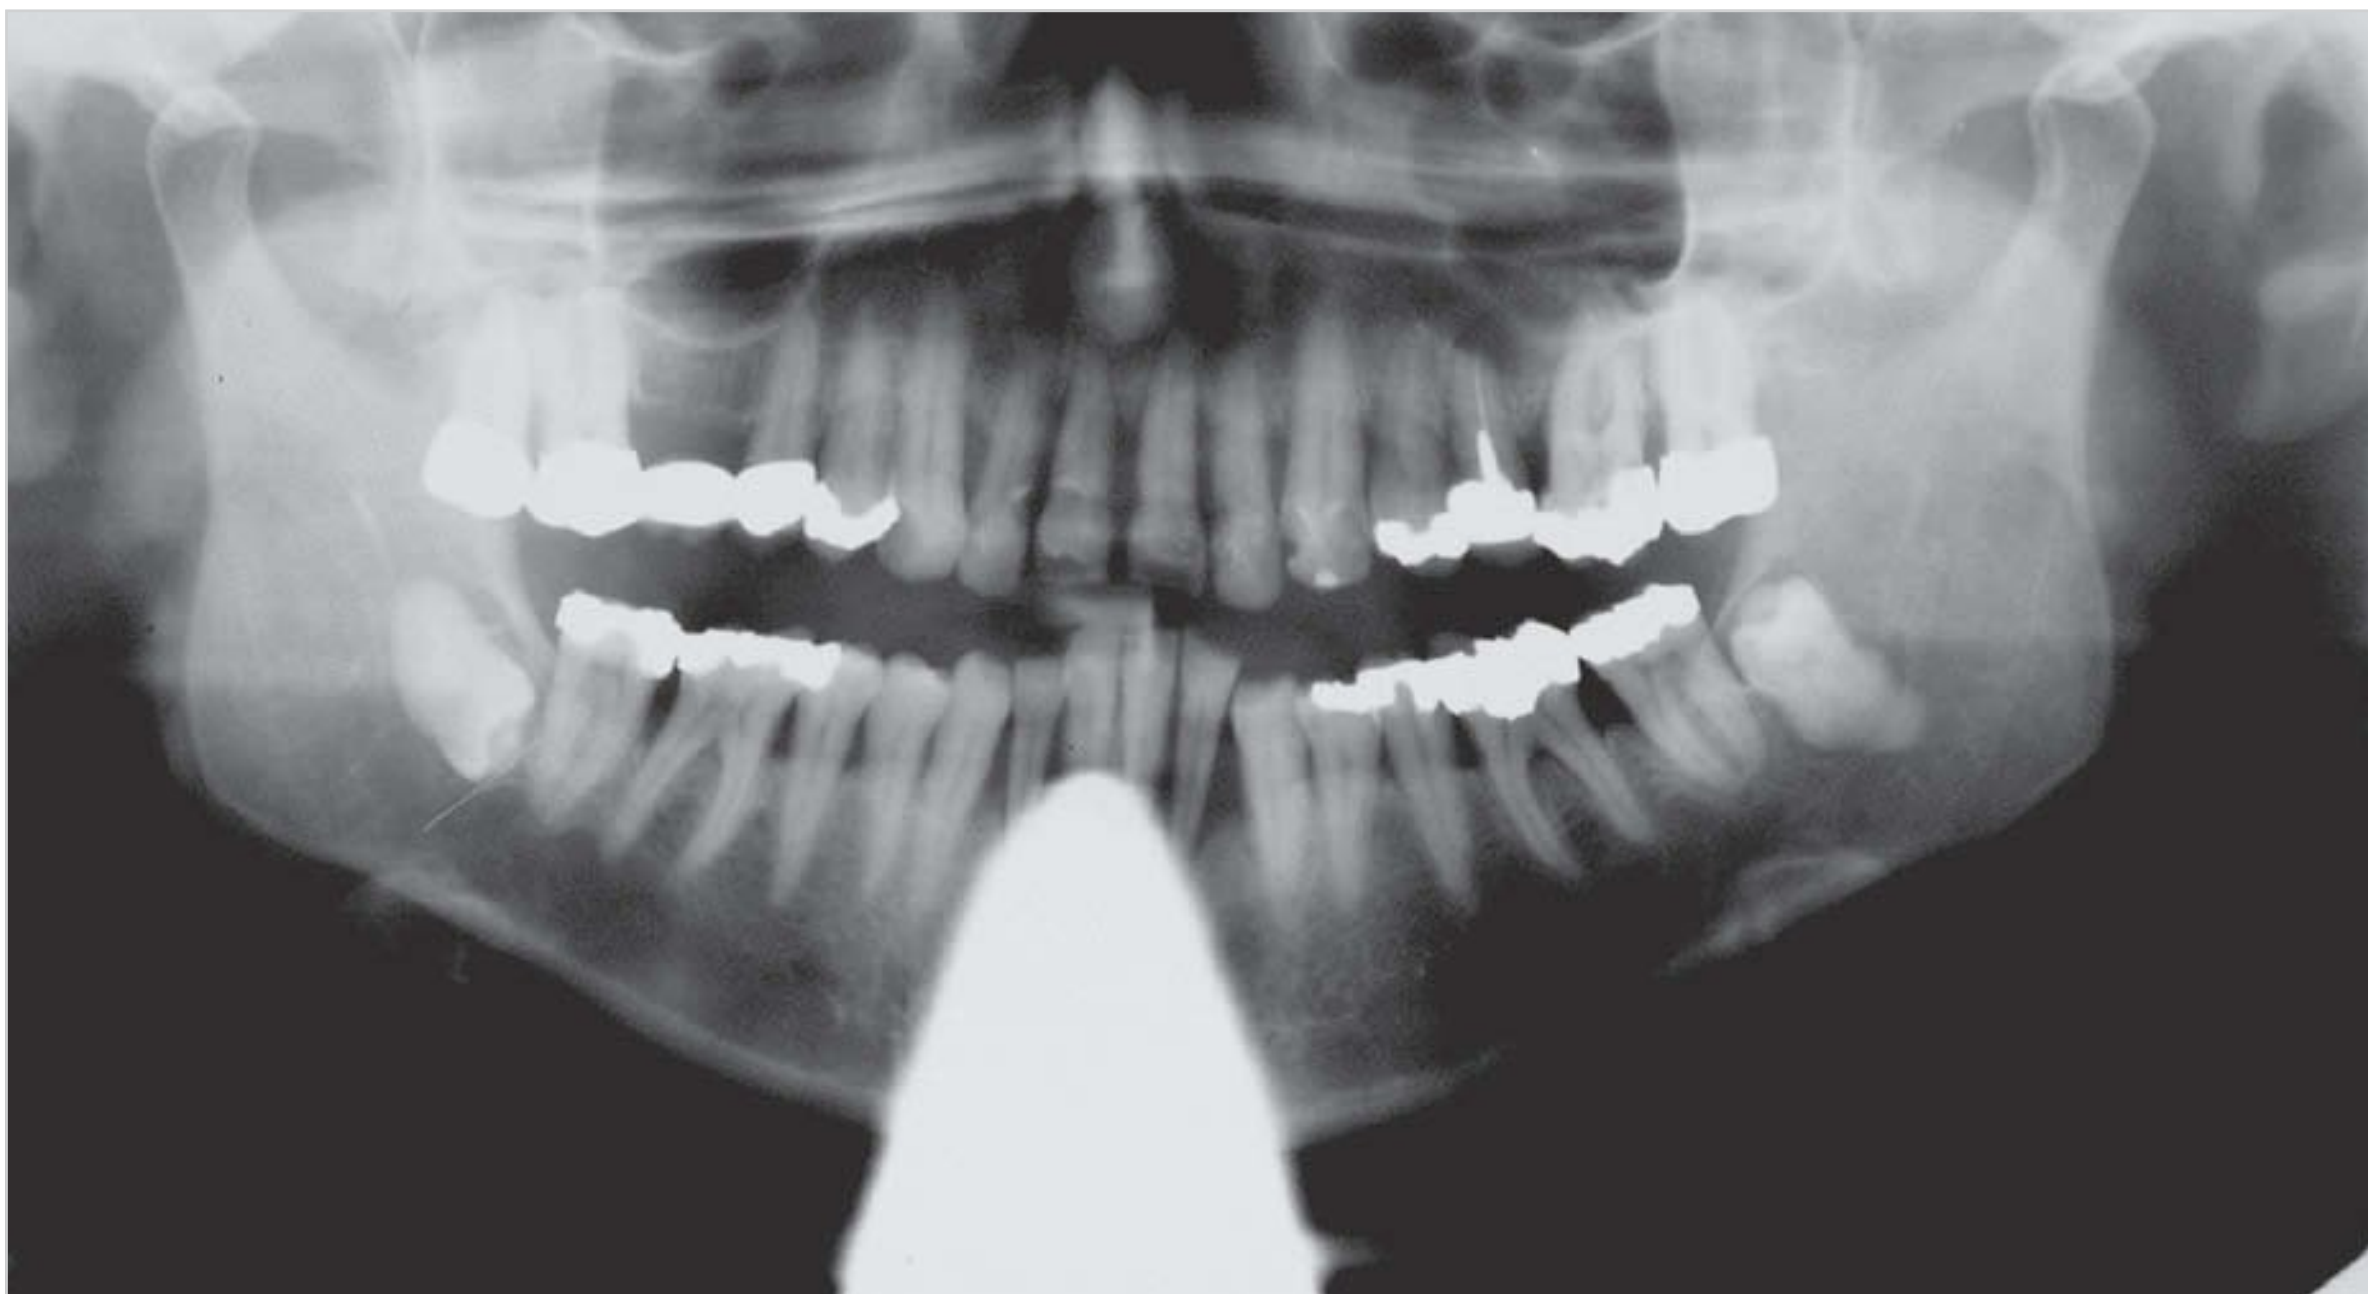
Lead apron artifact projected on the anterior region of a panoramic radiograph.
